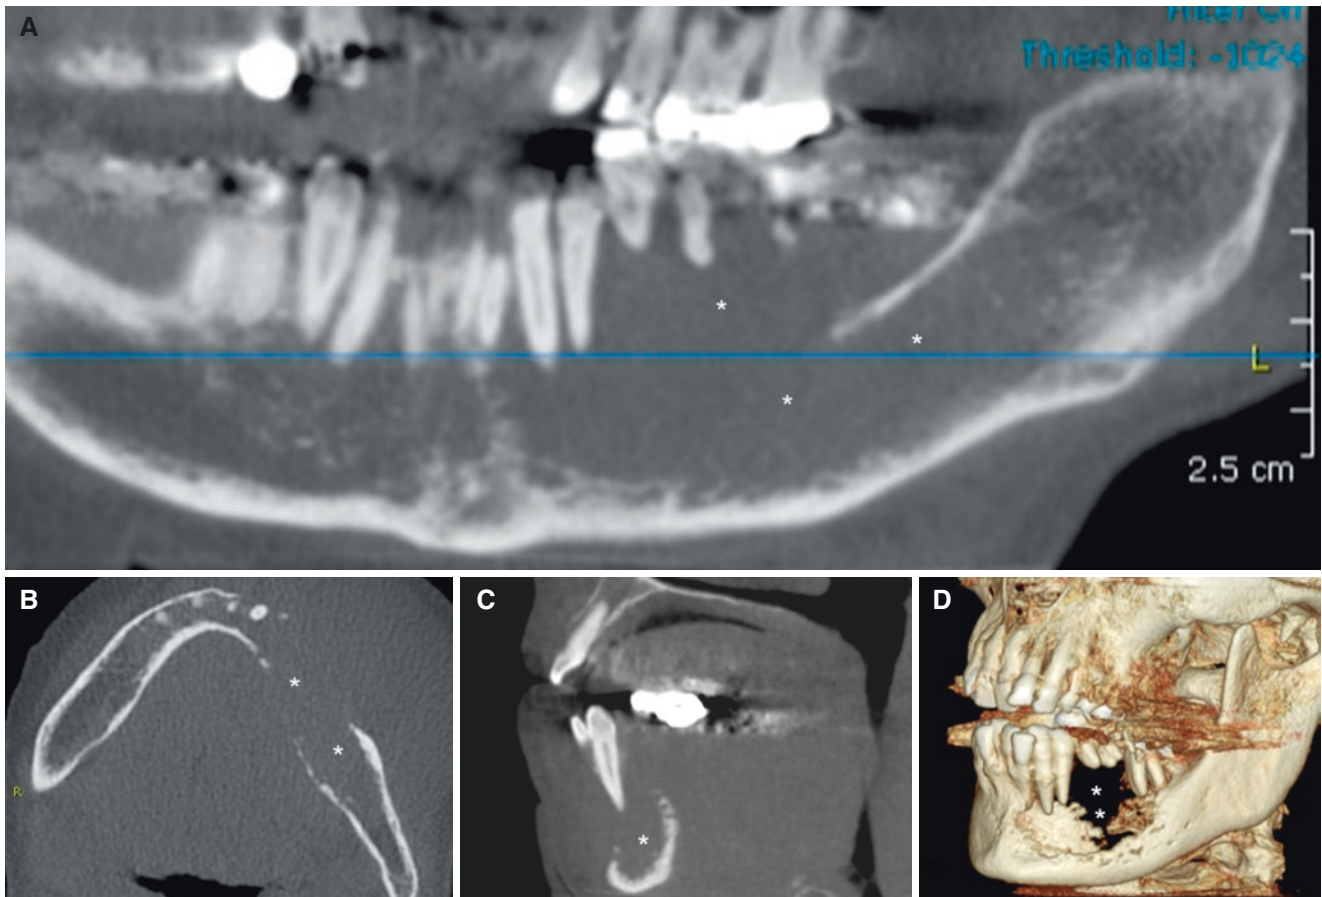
Multiple myeloma, mandible; 62-year-old female, known widespread disease, now with discomfort with bite (dental occlusion) and facial asymmetry having developed during the last 3 months. (A) Panoramic, (B) axial, (C) sagittal, and (D) 3D CBCT images show
